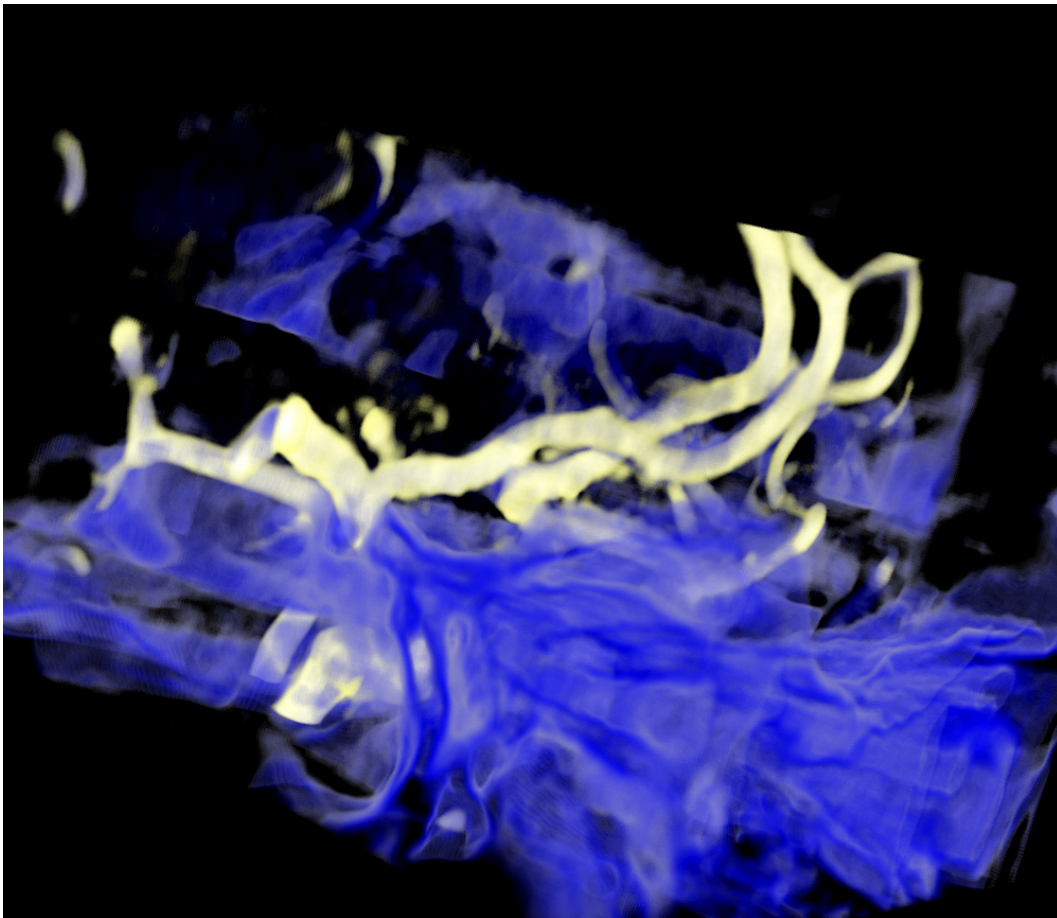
Results Aneurism 1. Volume renderings of MRI T1 (*blue*) and MRA (*yellow*) after registration.
